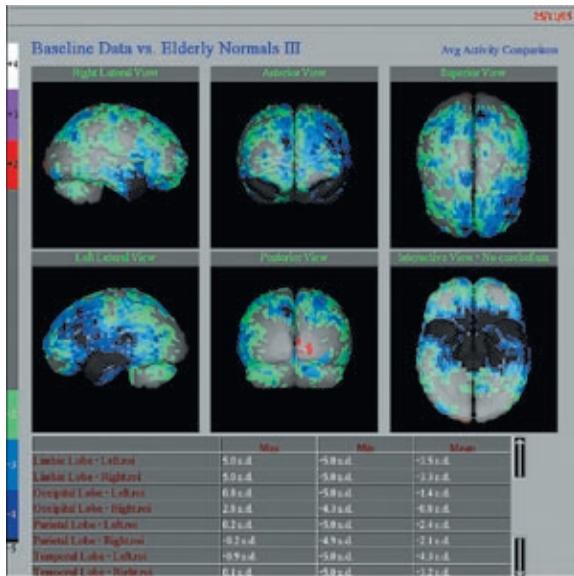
SPECT scans indicate bilateral profound decrease of perfusion/metabolism in both temporal lobes, more significant on the left side. Moderate decrease of perfusion/metabolism in frontal lobes bilateral, more significant on the left side also.
